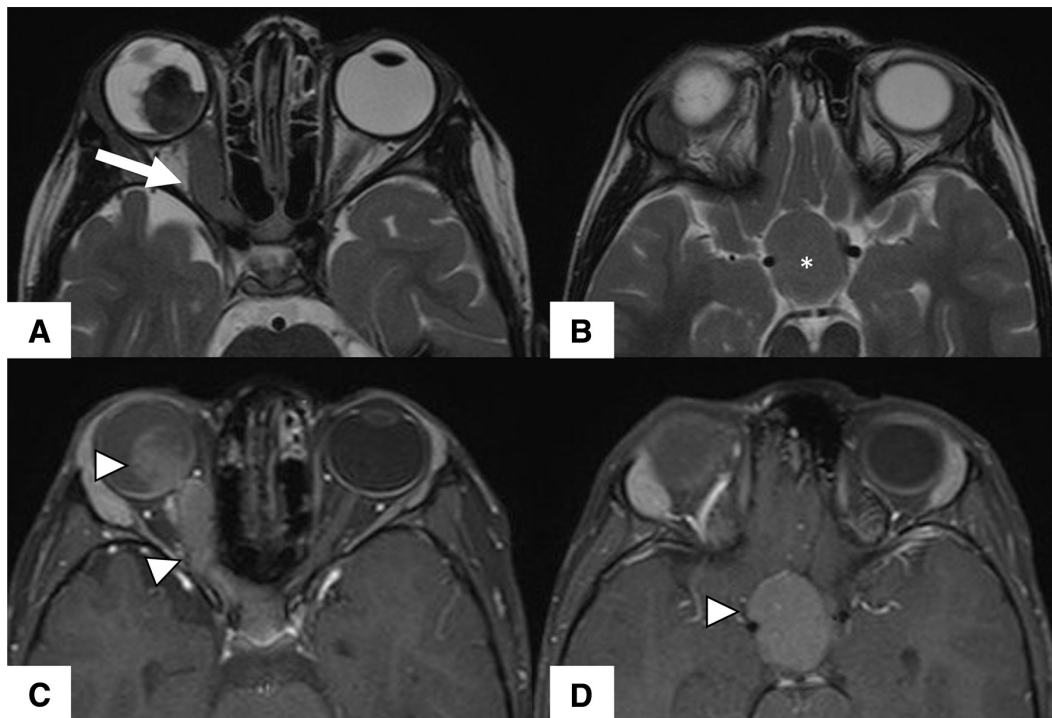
Retinoblastoma in the right eye with optic nerve invasion. Axial T2-weighted (A and B) and T1-weighted postcontrast (C and D) sequences show a retinoblastoma associated with thickening of the ipsilateral optic nerve (*white arrow*) and optic chiasm (*asterisk*). After the administration of intravenous contrast, there is enhancement of the retinoblastoma, the right optic nerve, and the optic chiasm (*arrowheads*).
